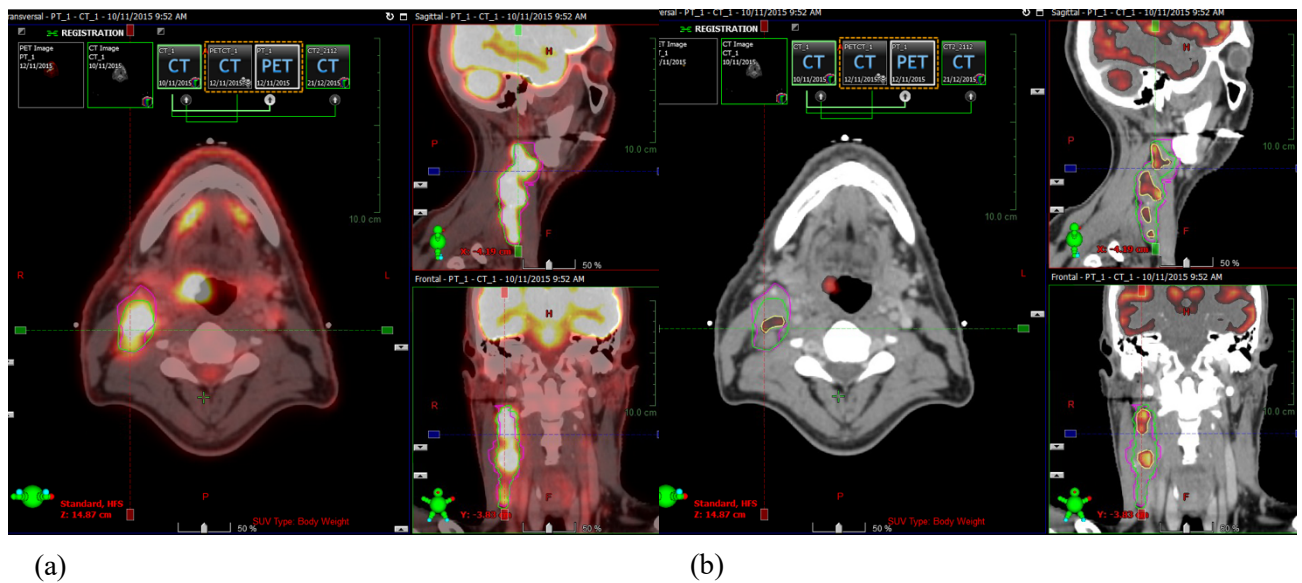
Patient with bulky N3 disease in the right neck. (a) Nodal tumour defined on CTsim (magenta), PET/CT with visual assessment (green) and (b) 50% threshold of SUVmax (yellow) are shown.
